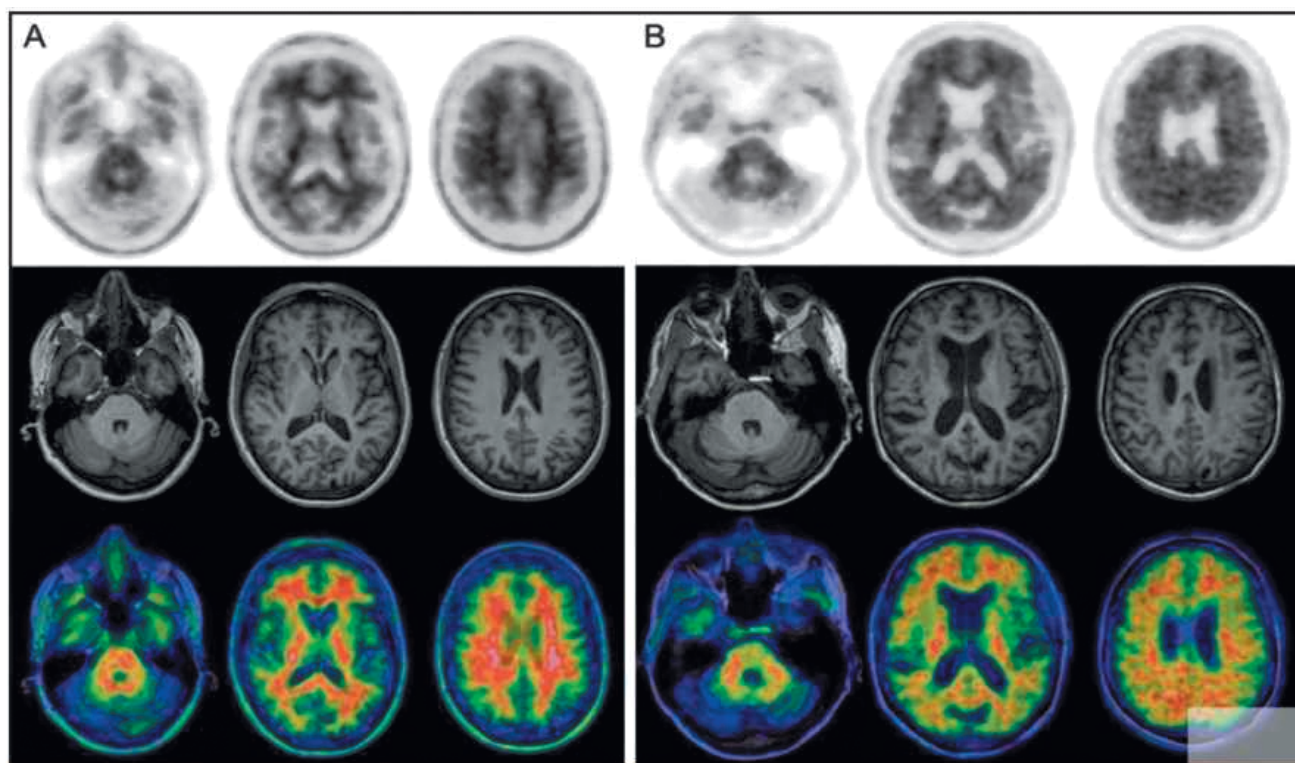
Amyloid imaging with ^{18}F -florbetapir. A) Normal control subject with no-to-sparse $\text{A}\beta$ plaques. B) Positive PET/MRI study, consistent with moderate to frequent $\text{A}\beta$ plaques²⁰.
